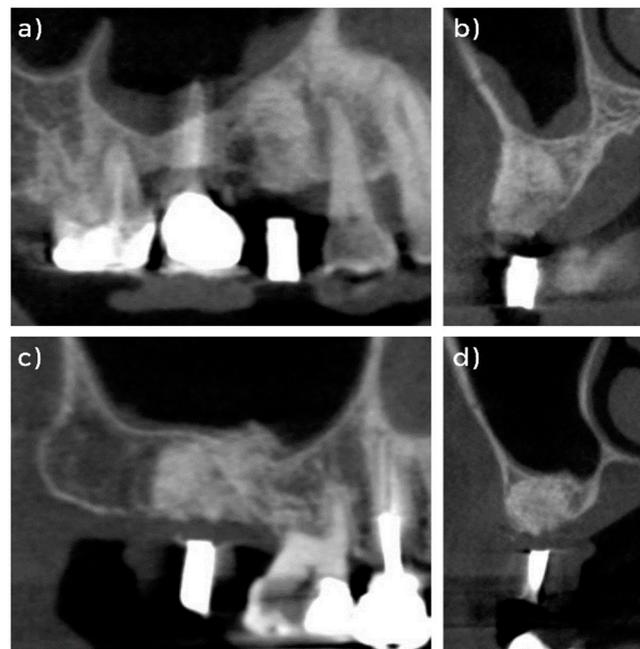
CBCT images of Case I (a) lateral view, (b) cross-sectional view taken one year after alveolar ridge preservation (ARP); Case II (c) lateral view, (d) cross-sectional view taken two years after ARP.
